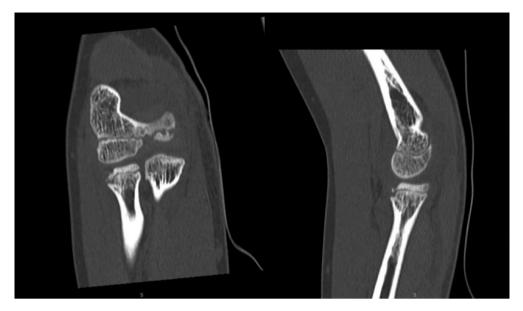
Coronal and sagittal computed tomography scans of right elbow in case 2 showing Salter-Harris type IV proximal radius fracture.
